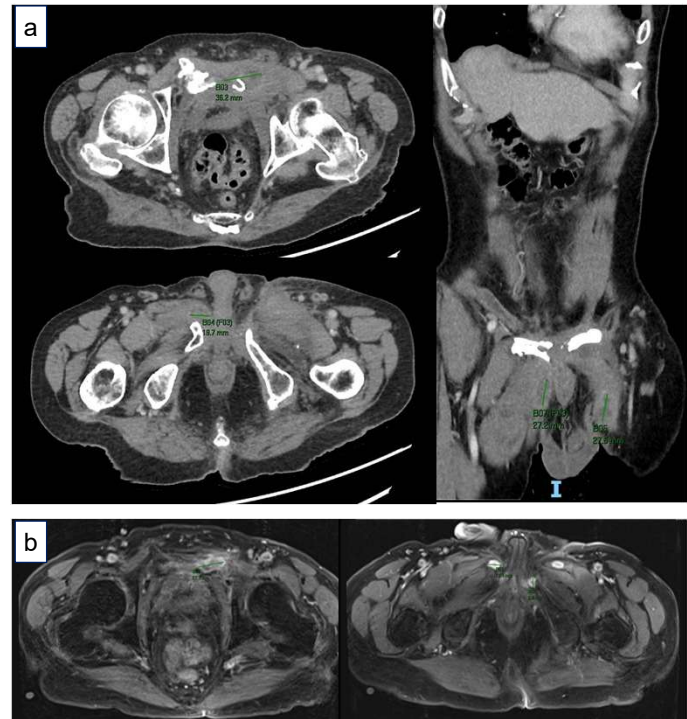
Image a: CT Abdomen Pelvis showed known non-united fractures of the pubic tubercle and bilateral superior pubic rami with small fluid collections surrounding the pubic symphysis.
